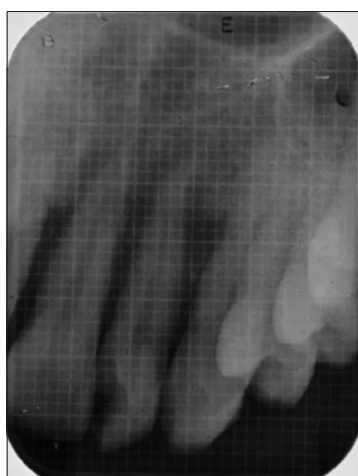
Radiograph with grid over maxillary anterior tooth
